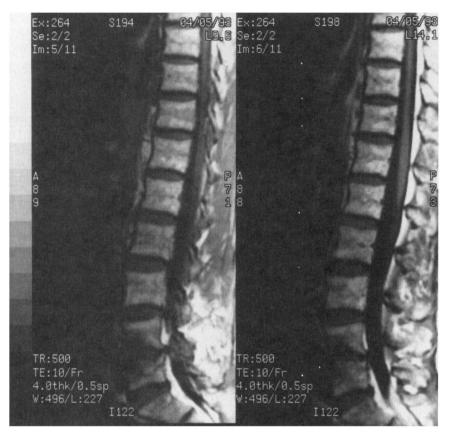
Case 1: magnetic resonance imaging scans performed 3 years after the patient's original presentation. The T1 sagittal scans show destruction of the L4/5 disc and vertebral bodies, which had not changed since the original X ray.
